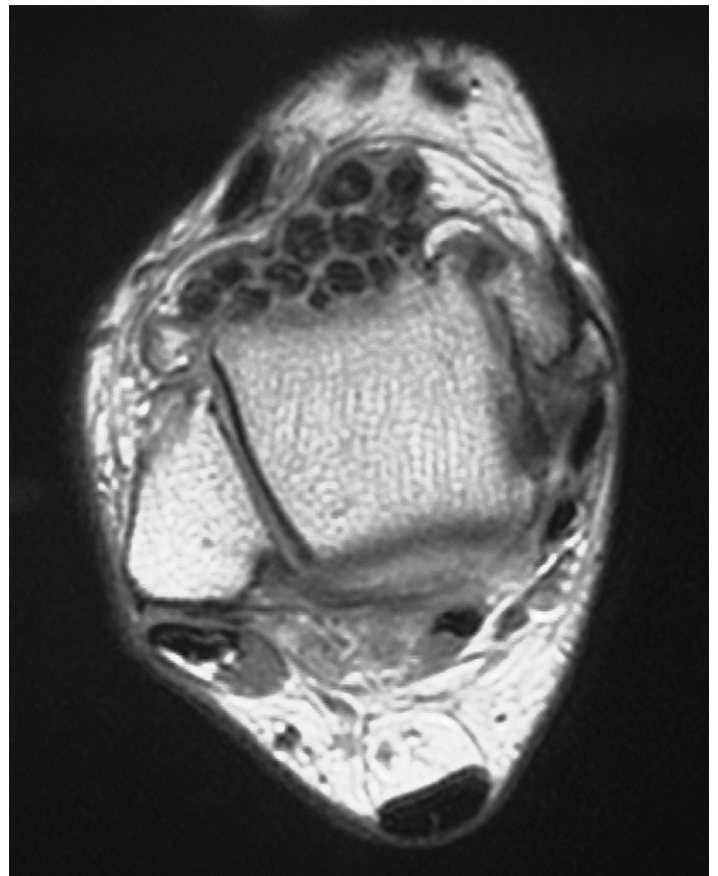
T1-weighted axial magnetic resonance image scan showing multiple osteocartilaginous bodies, focal low-intensity areas within each body, well-defined rim with the central aspect isointense to muscle, with synovial hyperplasia.
